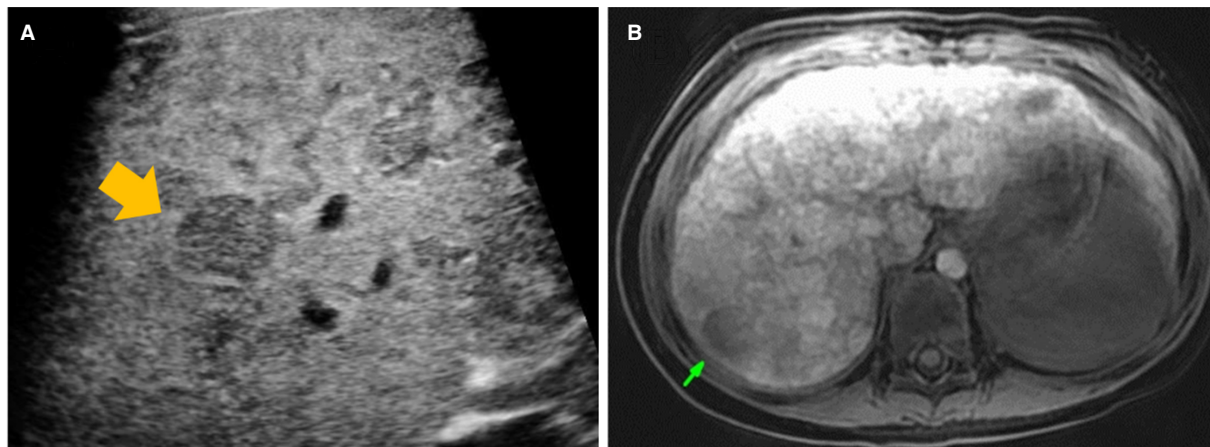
Abdominal ultrasound showed the mass in the liver (A). EOB-enhanced magnetic resonance images indicated the washed-out portal-venous phase and liver-cell-enhance phase in S7 hepatic mass (B)
